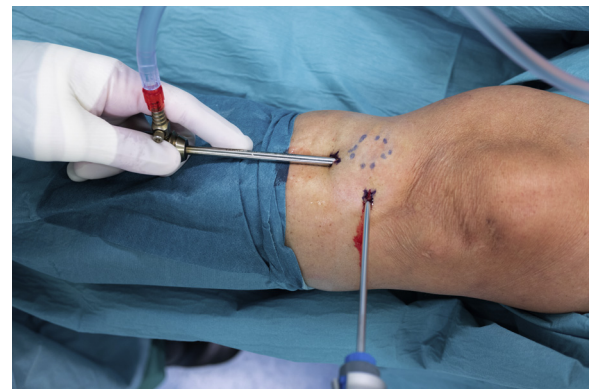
Perioperative image of the left knee of a patient about to undergo an endoscopic removal of a tibial cyst and the contained resorbable screw remnants. The localization of the broken head and the surrounding cyst has been determined by ultrasound examination. The cyst has been marked on the skin by a waterproof marker (dotted line circle). The broken screw head is situated in the center of the marked circle. The arthroscope cannula enters the cyst area from a small incision 2-3 centimetres below the screw head. The 3.5-mm soft-tissue resector enters the same area from an incision 2-3 cm laterally to the screw head.
